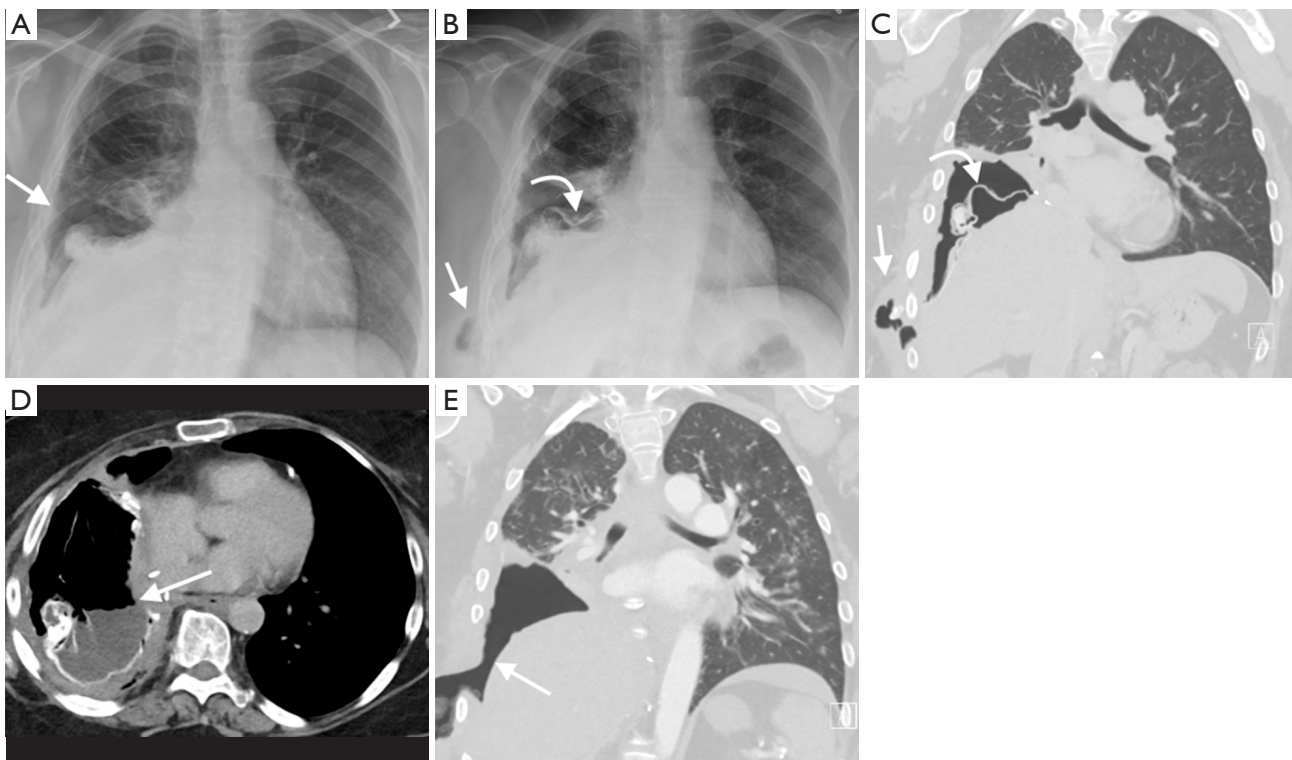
A 65-year-old woman with right epithelioid mesothelioma underwent a right EP/D with diaphragmatic reconstruction. CXR 2-year post-op (A) demonstrates a persistent loculated right basal hydropneumothorax (arrow). The patient subsequently presented two and a half years post-surgery with fever and purulent chest wall discharge. CXR (B) demonstrates new subcutaneous gas in the right chest wall (arrow) and new gas under the right diaphragmatic reconstruction (curved arrow), concerning for empyema formation. Coronal image from a CT thorax (C) demonstrates a right lateral chest wall gas and fluid collection (arrow) and air under the diaphragmatic reconstruction (curved arrow). Axial image from a CT thorax (D) demonstrates a collection under the right diaphragmatic reconstruction with an air-fluid level (arrow), concerning for empyema. The diaphragmatic flap was removed, the empyema evacuated and a right Clagett window formed, as demonstrated on this coronal image from a post-contrast CT thorax (arrow, E). A small bronchopleural fistula was found during the operation, and the drained fluid grew *Aspergillus sp.* EP/D, extend pleurectomy/decortication; CXR, chest radiograph; CT, Computed tomography.
